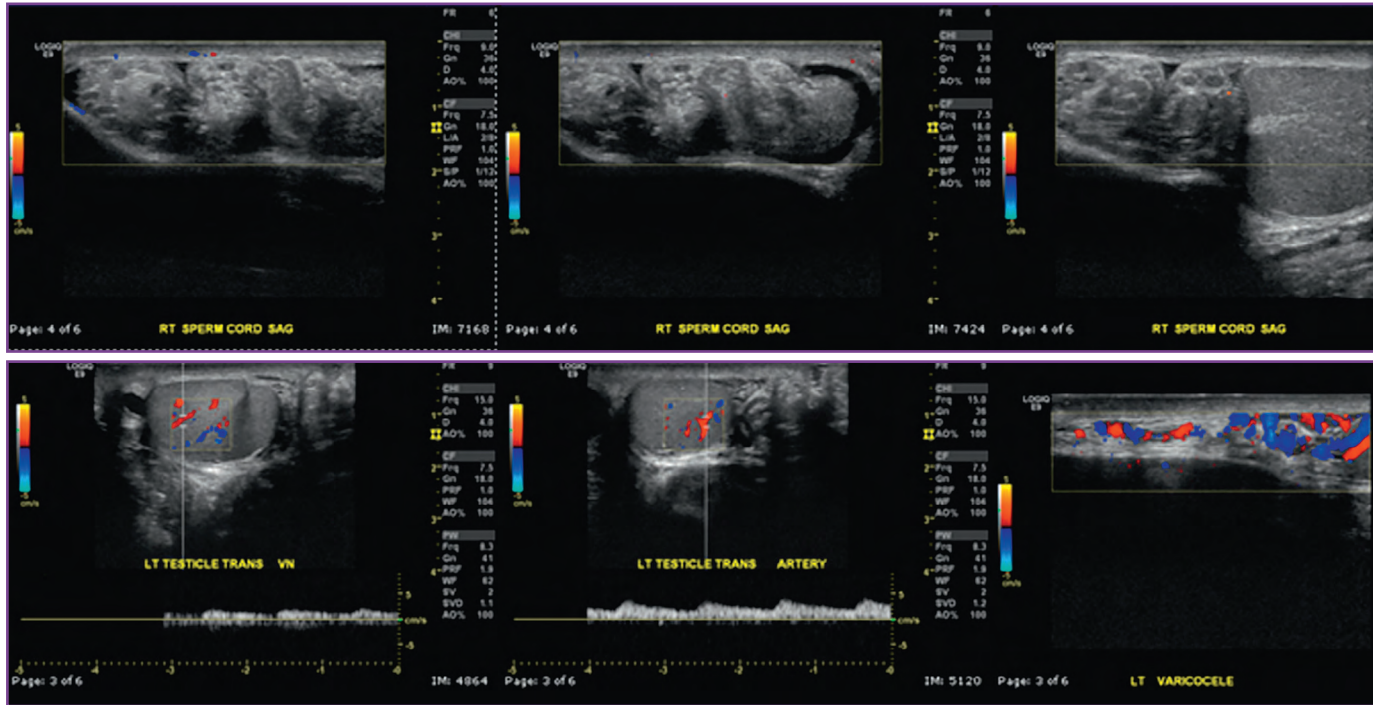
Absence of flow to the right testis and epididymis at Doppler ultrasonography, with normal flow to the left testis, consistent with right testicular torsion.
